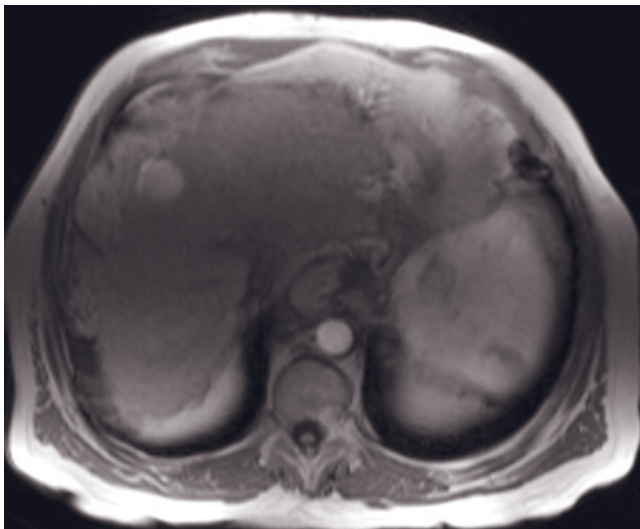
(Continued) (i) postgadolinium SGE in a second patient; and T2-weighted SS-ETSE (j), SGE (k), out-of-phase SGE (l), and immediate (m) and 90-s fat-suppressed (n) postgadolinium SGE in a third patient, all with a small hypervascular HCC. Note that in all cases the tumor has intense enhancement on early-phase images and washout with late capsule enhancement on late-phase images.
